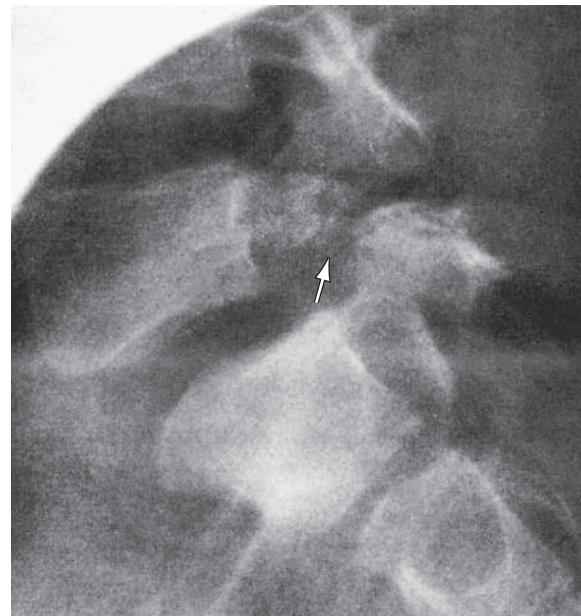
Defect in the pars interarticularis (arrow) of the neural arch of L5 (spondylolysis) that has permitted the body of L5 to slip forward (spondylolisthesis) on the body of S1. (From Silverman FN, Kuhn JP. *Essentials of Caffrey's Pediatric X-ray Diagnosis*. Chicago: Year Book Medical Publishers; 1990:95.)
